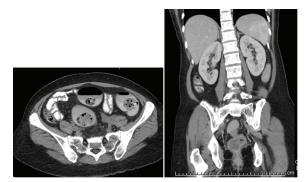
A follow-up CT scan in Oct 2012 (3 months after <sup>131</sup>I-rituximab revealed no residual lymphadenopathy. Resolving left hydronephrosis is observed.
